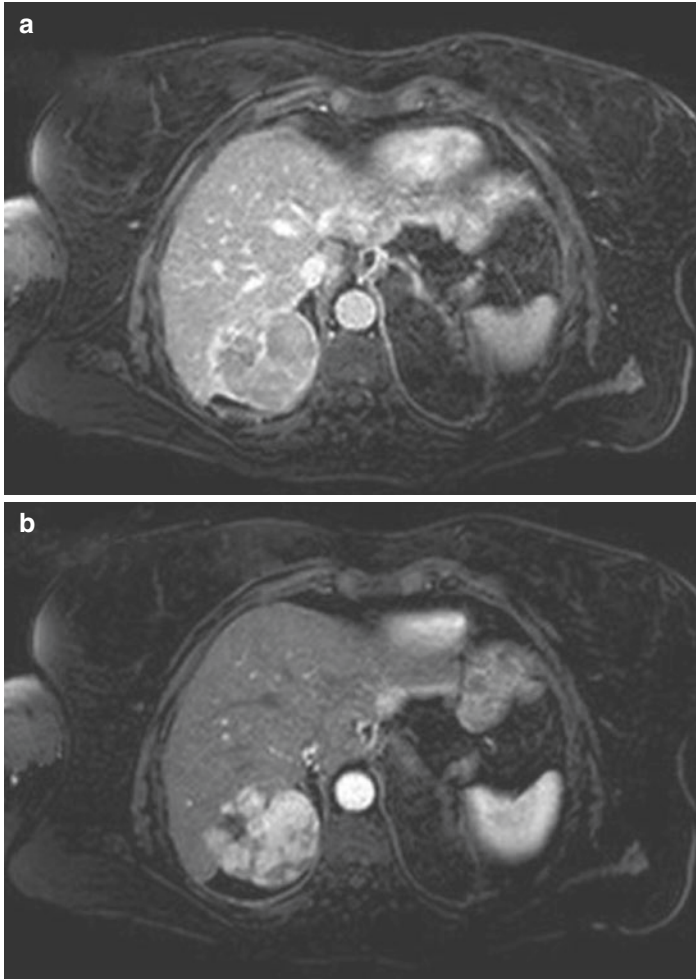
MRI liver with gadolinium enhancement. (a) A large hypovascular lesion is seen in segment 7 on the delayed phase imaging. This shows arterialization in the arterial phase (b) and then shows washout in the portal venous phase and venous phase (c). This lesion demonstrates the classical hallmarks of a HCC
